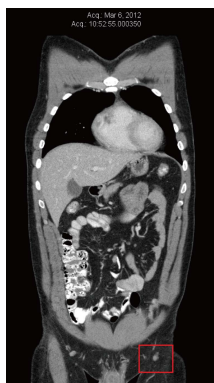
Computed tomography scan from March 2012 prior to natural therapies and prior to dichloroacetate therapy. Largest node measured 8 mm in diameter.
